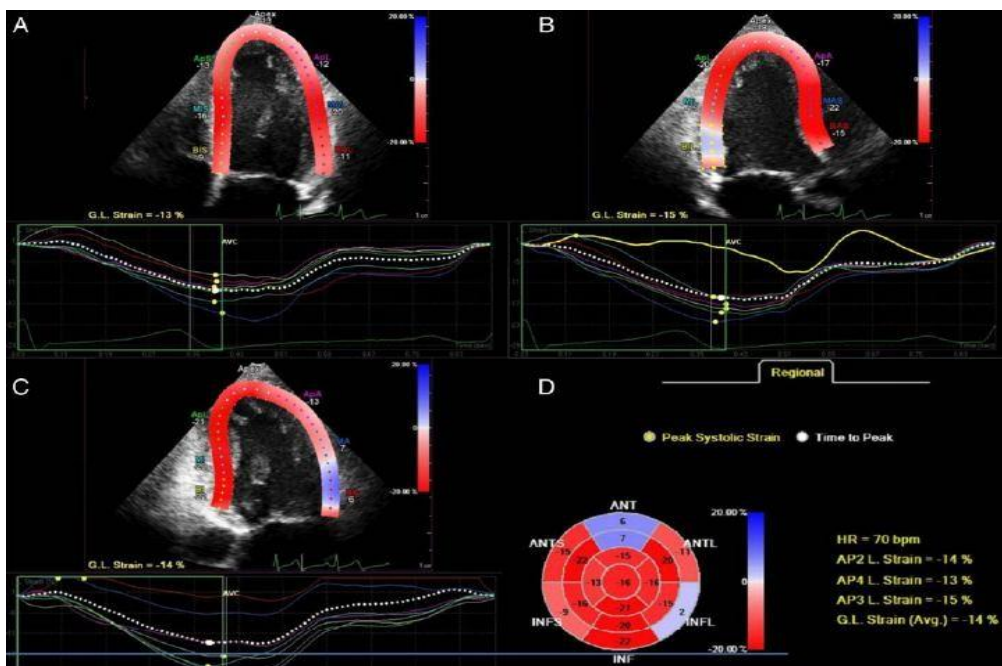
Longitudinal strain acquired from AP4C, AP2C and AP3C AP4C: apical four chamber, AP2C: apical two chamber, AP3C: apical three chamber and GLS: global longitudinal strain (50).
